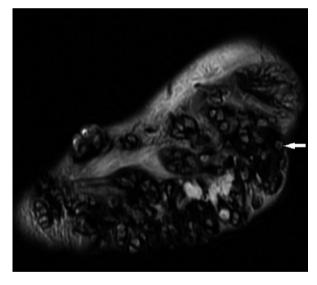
Magnetic resonance imaging scan of the foot showing 'dot in circle' sign.
